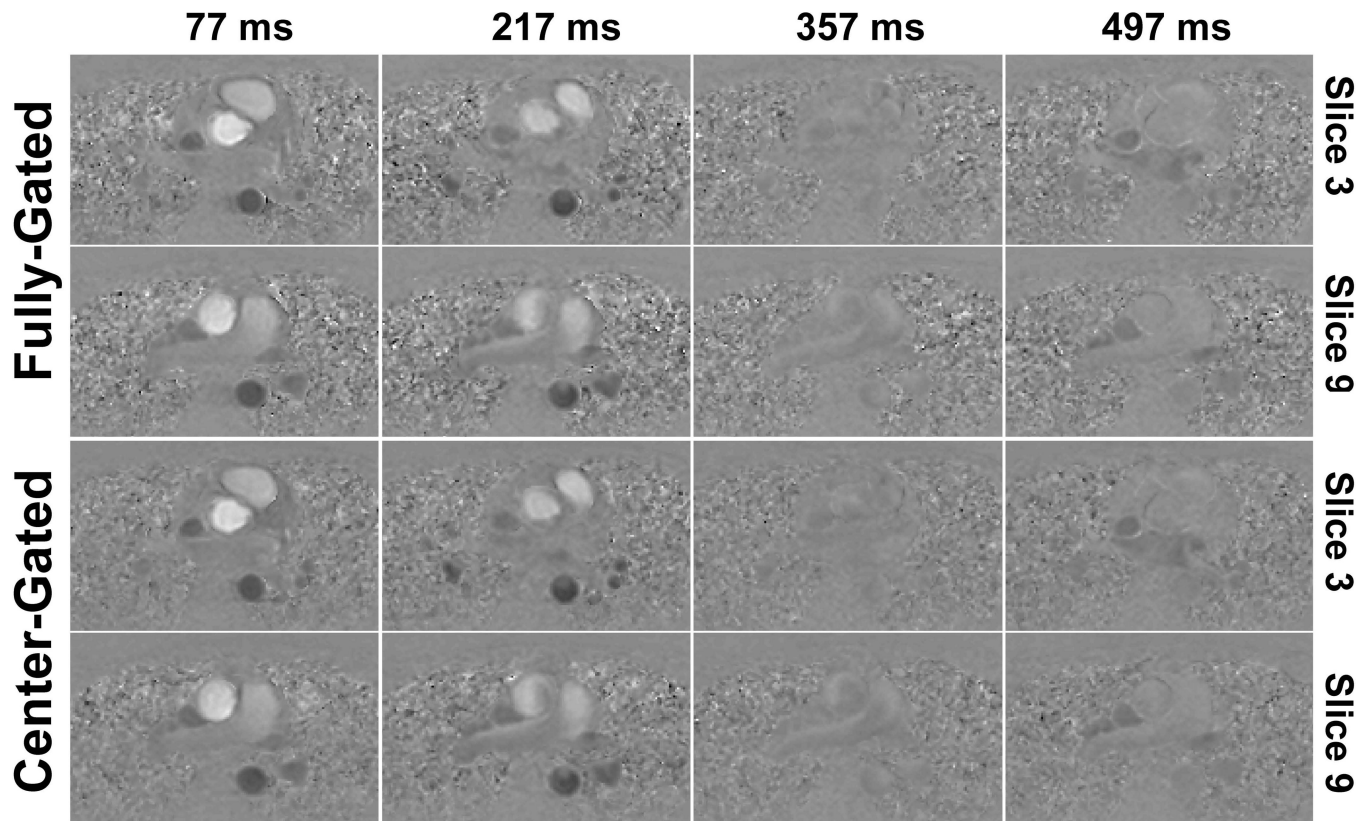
Example phase images for two slices and various cardiac phases (specified by time after the R wave) of 3D PC MRI acquisitions from the same subject of Figure 2. The phase images show similar flow patterns through the ascending and the descending aorta, and any motion corruption at the edges of the k-space does not hinder the visualization of these patterns.
